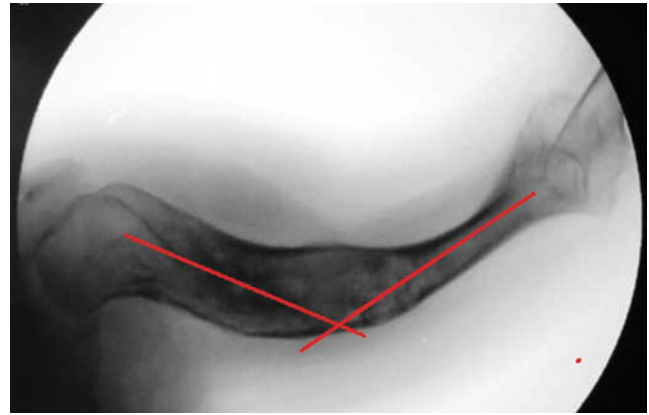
Fluoroscopy left humerus: preoperative radiographs underestimate the magnitude of the deformity because of its oblique nature. The fluoroscopic image demonstrates the true oblique plane deformity that is consistent with the physical appearance. The apex of the deformity is anteromedial
